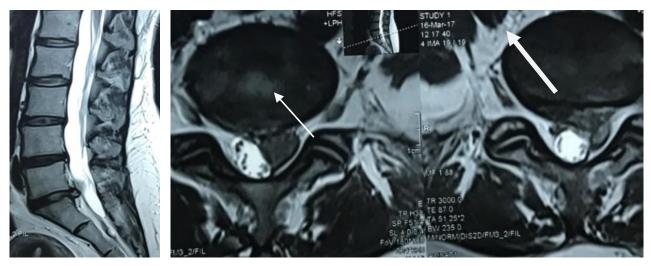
(a) Sagittal T2-weighted magnetic resonance image (MRI) shows lumbar disc herniation at L5-S1 level and corresponding (b, c) Axial T2 -weighted MRI shows left sided disc herniation causing root compression (arrow mark). Limited discectomy was done.
